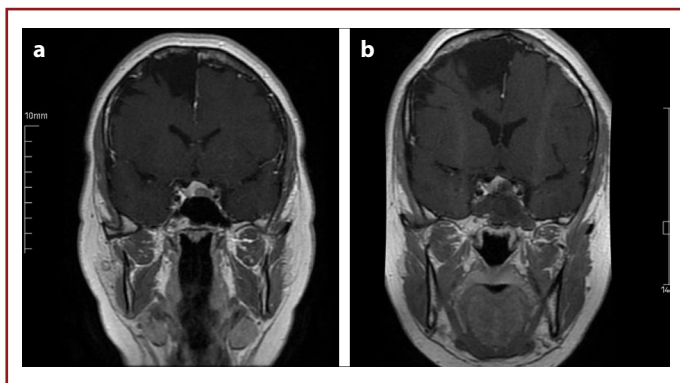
(a) Preoperative (b) Post-operative post-contrast T1 sequence magnetic resonance imaging of patient 5.
